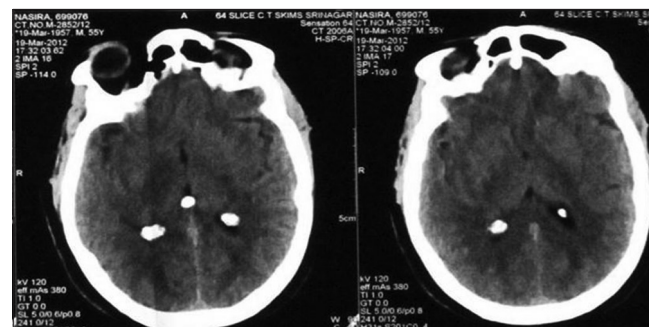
Non contrast CT head with choroid plexus hyperdensities
